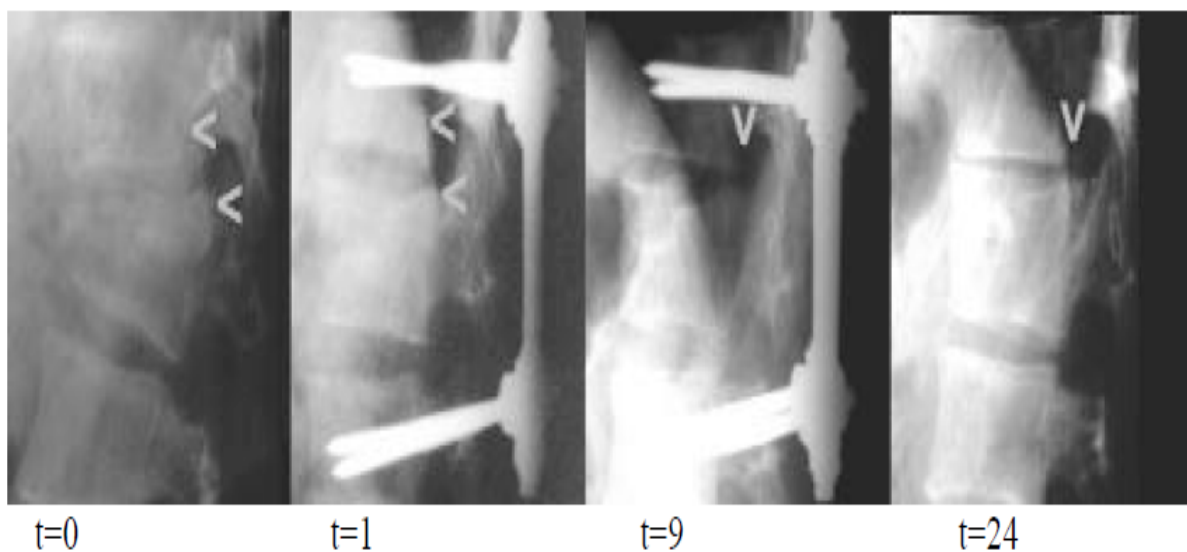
Recognizable bony narrowing in plain lateral radiographs. Follow-up 24 months after initial surgery after t= 0, and removal of the internal fixation after 9 months.
